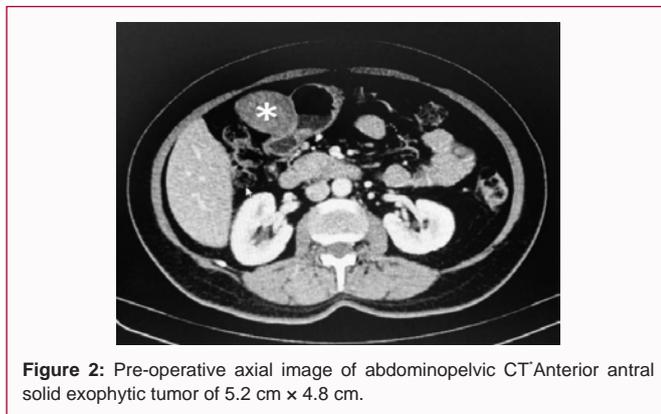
Pre-operative axial image of abdominopelvic CT Anterior antral solid exophytic tumor of 5.2 cm x 4.8 cm.
